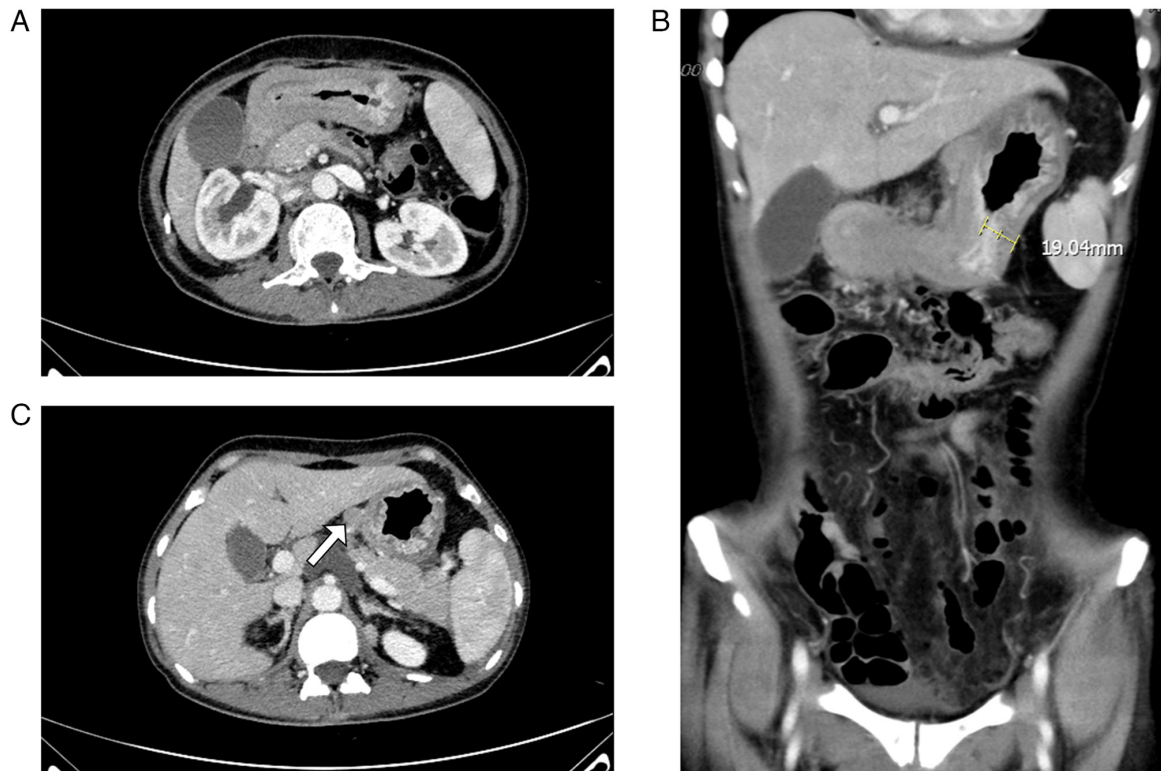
Follow-up contrast-enhanced CT imaging revealing disease progression. (A) Axial CT image shows diffuse and irregular gastric wall thickening with heterogeneous enhancement. (B) Coronal CT image demonstrates progressive, diffuse and irregular wall thickening extending from the gastric fundus/body to the pyloric region, with heterogeneous enhancement. (C) Axial CT image reveals a newly enlarged nodule within the hepatogastric ligament, highly suggestive of metastatic involvement.
